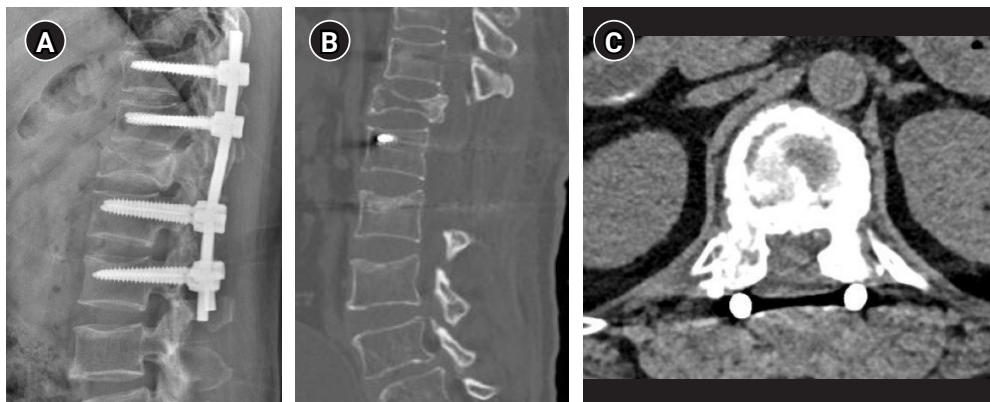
Postoperative imaging. (A) Postoperative X-ray indicating spinal fusion from T10 to L2, demonstrating successful instrumentation and alignment post-surgery. (B) Postoperative computed tomography (CT) sagittal scan showing a well-decompressed state at the T12, L1, and upper L2 levels. The previously noted calcified lesions are no longer visible. (C) Postoperative CT axial scan at the T12 level, confirming the absence of the calcified lesion on the central canal and effective decompressive laminectomy.
